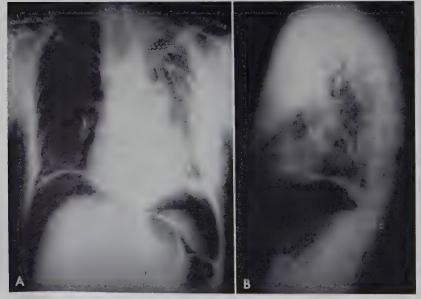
(Case I). Anteroposterior and lateral roentgenograms of the chest immediately after operation show the efficacy of pneumoperitoneum as an adjunct in adjusting the volume of the left hemithorax to the volume of the remaining lobe. Note that the mediastinum is not shifted.
